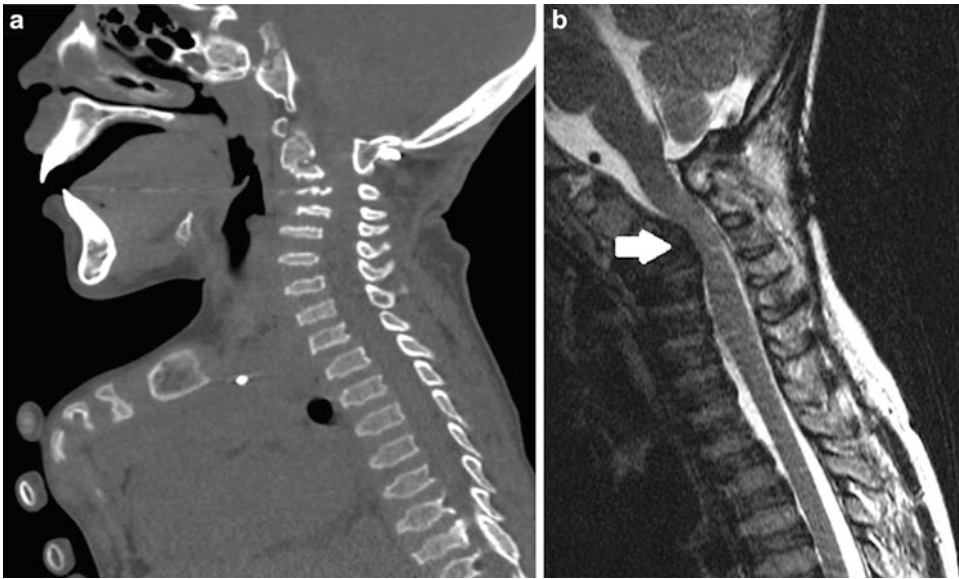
(a, b) A 9 year old male with a history of mucopolysaccharidosis IV (Morquio syndrome), cervical spine instability, restrictive lung disease, hearing loss, and arrhythmia. Multiple imaging studies demonstrated generalized osteopenia and Morquio syndrome related bony deformities (not shown). Sagittal cervical CT (a) image showed skeletal dysplasia with flattened irregular vertebral
